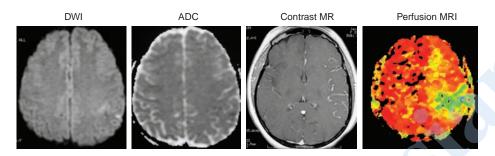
Perfusion/diffusion mismatch. Acute left ICA occlusion in a 29-year-old woman. There are very small diffusion defects in the left posterior frontal lobe. Perfusion MRI shows that the full left MCA territory is at risk. (Courtesy of Dr. Lotfi Hacein-Bey.)
